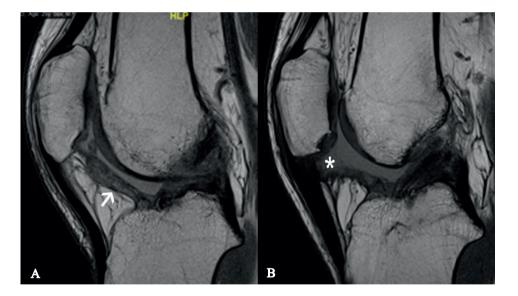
Decreased ROM after Dynamic Intraligamentary Stabilization repair due to arthrofibrosis. Sagittal proton density weighted MR images at 12 months post-operatively (A) show extensive fibrosis in Hoffa's fat pad (arrow). Follow-up MRI assessment at 24 months post-operatively (B) shows status after arthroscopic arthrolysis with resection (asterisk) of Hoffa's fat pad. Note normal healing of the ACL repair.
